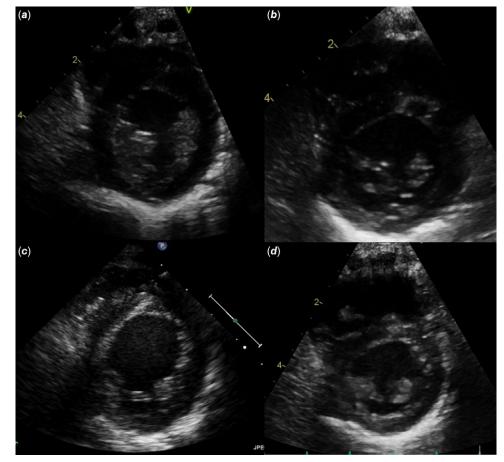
Parasternal short-axis images at end-diastole at the level of the papillary muscles. (*a*) Case 1 baseline assessment demonstrating concentric left ventricular hypertrophy. (*b*) Following adequate hypertension control, normalisation of LVH occurred. (*c*) Case 2 baseline assessment demonstrating mild left ventricular dilation with reduced systolic function. (*d*) Following adequate hypertension control, there was normalisation of left ventricular dimension and systolic function. See Online Video for echocardiographic loops corresponding with these images.
